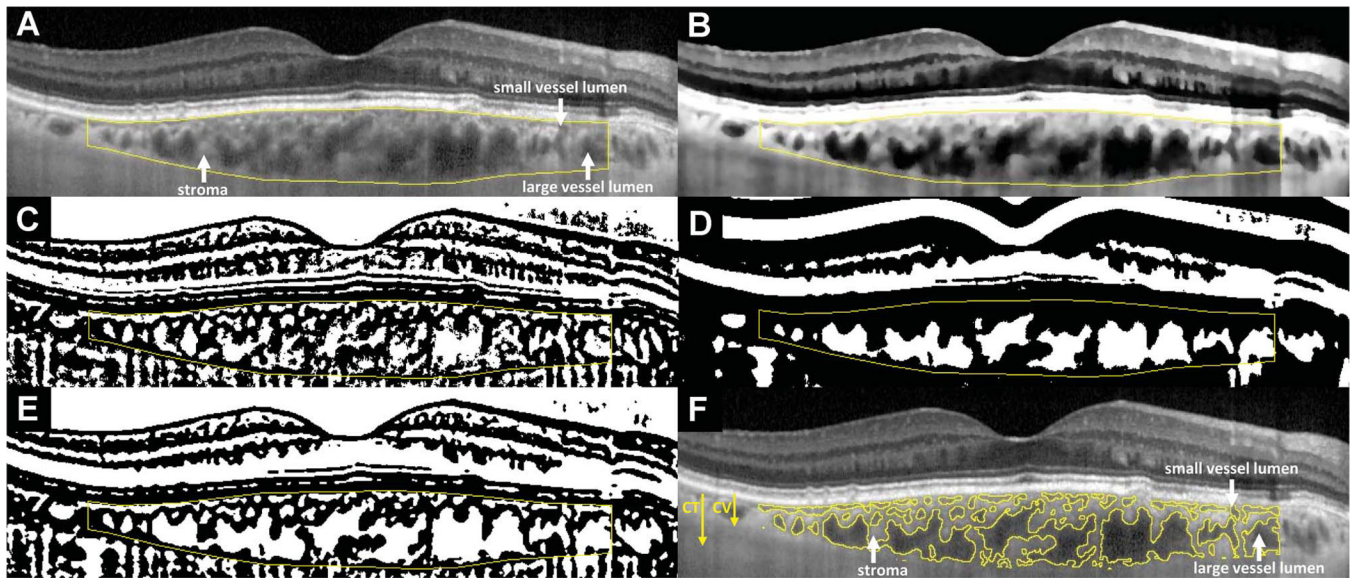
Choroidal segmentation algorithms used for the analysis of EDI-OCT images to calculate choroidal parameters. Horizontally oriented EDI-OCT B-scans traversing the center of the fovea were analyzed. Manual segmentation of the inner and outer borders of the choroid (A) was performed over the central 6-mm zone (3 mm on either side of the foveal center). These segmentation lines outlining the overall dimensions of the choroid were used in the computation of CT. For the segmentation of individual vascular spaces in cross-section from the nonvascular stroma, the original EDI-OCT image first underwent contrast enhancement, passage through a bilateral filter, and normalization to produce the processed image (B). Image binarization was performed once on the processed image for an optimized segmentation of small choroidal vessels using the Niblack autolocal threshold tool (C). A second separate image binarization procedure was performed on the processed image for a differently optimized segmentation of large choroidal vessels using Niblack thresholding with altered parameters (D). The two binarized images were then combined to produce a multiscale image, which underwent additional despeckling (E). This eventual image was then segmented into areas with contiguous black or white pixels, with the segments containing white pixels representing vascular luminal spaces, and the segments containing black pixels representing nonvascular choroidal stroma (F). Choroidal thickness arrow: CT, in μm , was defined as the total area of all pixels (black and white) within the segmentation outlines of the choroid, divided by the length of retina assayed (central 6 mm). CV arrow: CV thickness (in μm) was defined as the area of all white pixels (choroidal vascular spaces), divided by the length of retina assayed (central 6 mm). Hence, $\text{CT (all pixels)} = \text{CV (white pixels)} + \text{choroidal stromal thickness (black pixels)}$. Choroidal vascularity index was defined as the ratio CV:CT , expressed as a percentage.
